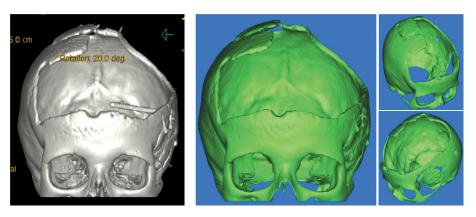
CT scan and segmented views of the skull showing the extent of bone to be restored.
